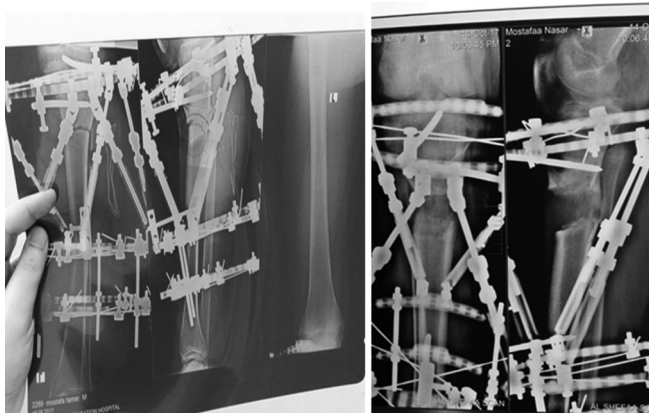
Radiography with TSF at the beginning and after 3 months. TSF, Taylor spatial frame.
